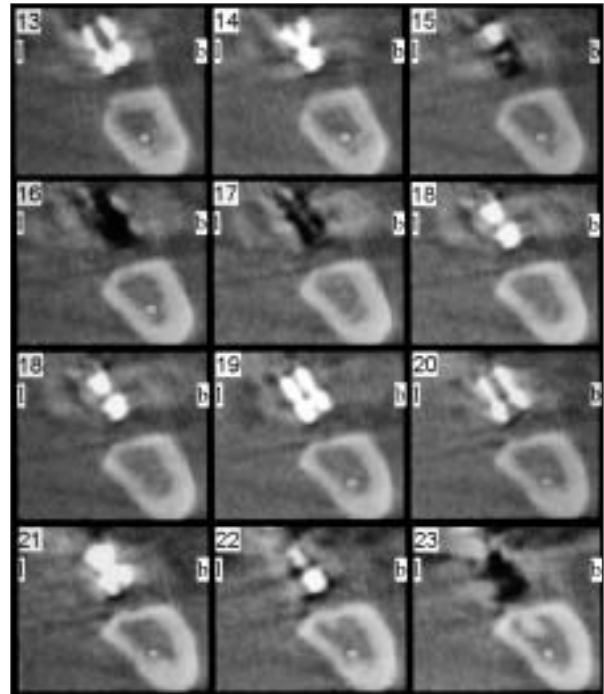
Preoperative CT showing parasagittal sections of the edentulous area.
